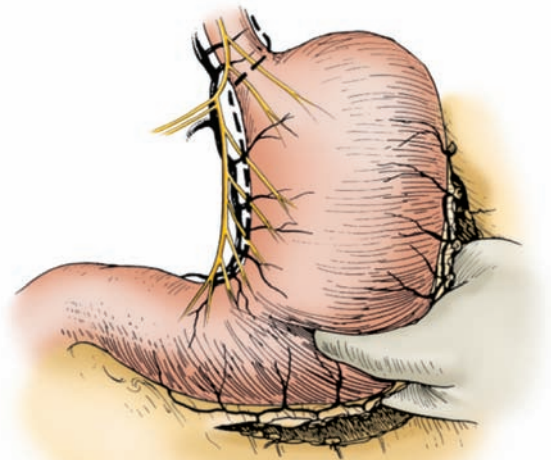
The distribution of the anterior vagus nerve is shown. The dotted line indicates the line of dissection. Note that it goes around the incisura to within about 6 cm of the pylorus. The gastrocolic omentum has been partially divided to permit access to the posterior nerve of Latarjet and to allow the stomach to be grasped and used as a retractor. Note that the gastroepiploic arteries are carefully preserved. (Redrawn, with permission, from Johnston D. Vagotomy. In: Schwartz SI, Ellis H, eds. *Maingot's Abdominal Operations*. 8th ed. Norwalk, CT: Appleton-Century-Crofts; 1985. After R.N. Lane.)
